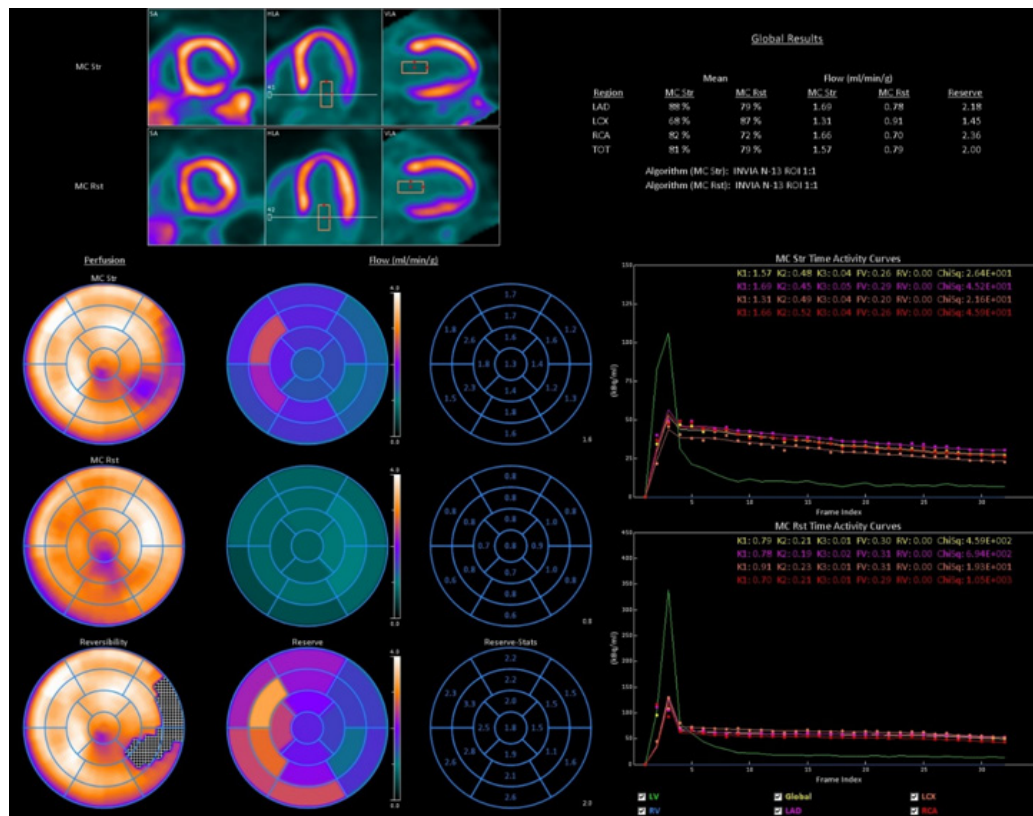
<sup>13</sup>N-NH<sub>3</sub> PET/CT images.
